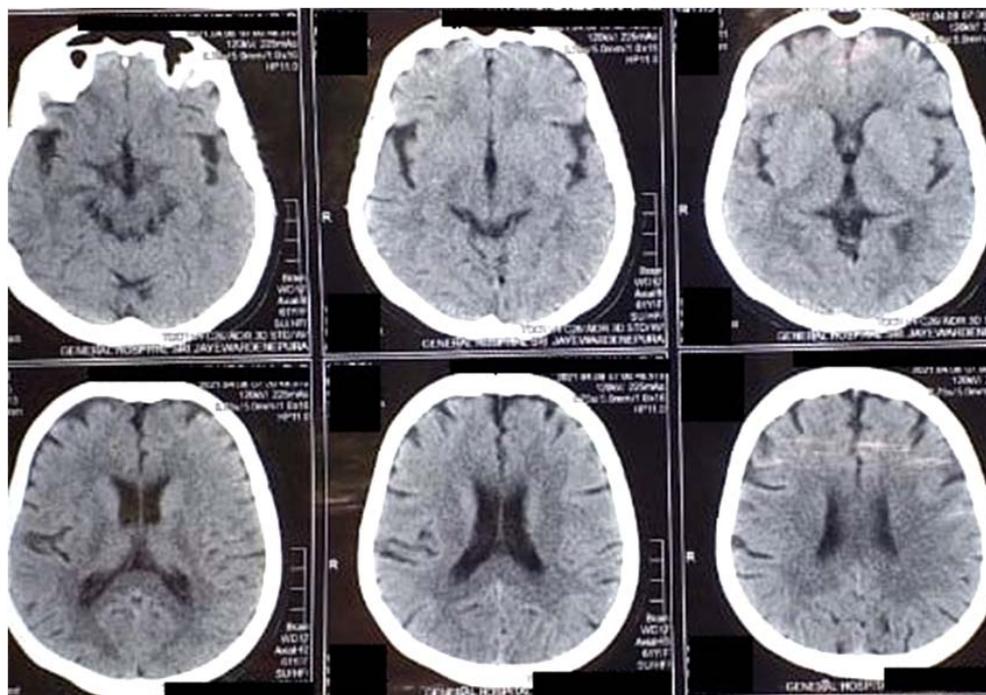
Normal non-contrast CT of brain on admission.
